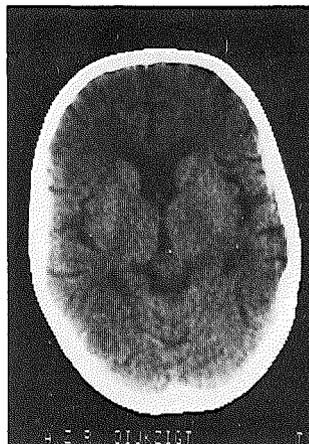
Follow-up of child #39; CT scans with different foveal distances
